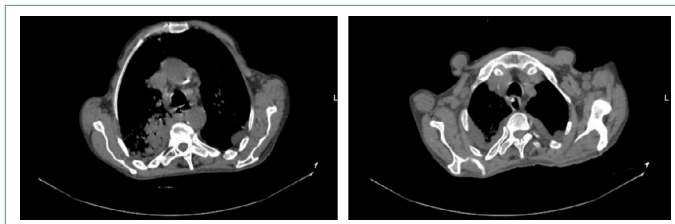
Thorax CT image of the patient in the intensive care unit shows disease recurrence.
